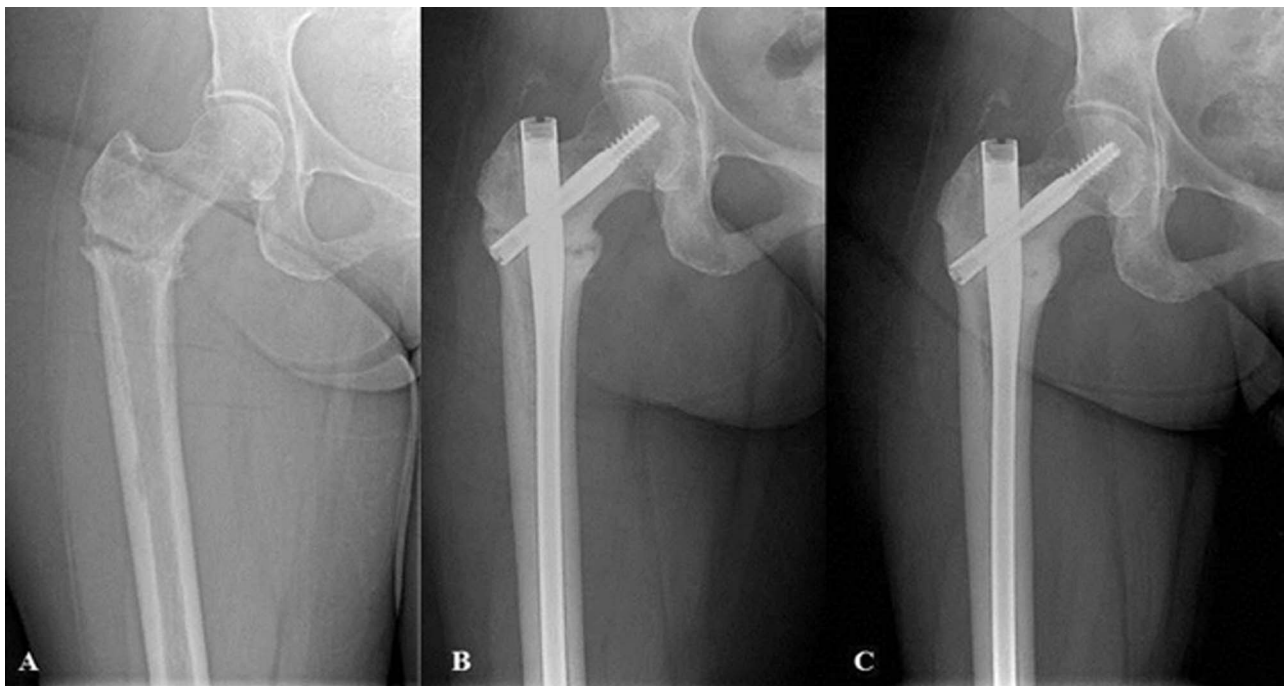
A-C A 59-year-old woman with metastatic breast carcinoma presented with a subtrochanteric femur fracture. (A) Pre-operative radiograph shows minimal displacement and a characteristic transverse fracture pattern. (B) Early postoperative radiograph demonstrates callus formation and reduction of the fracture. (C) The fracture is healed without recurrence of disease 36 months after surgery.
